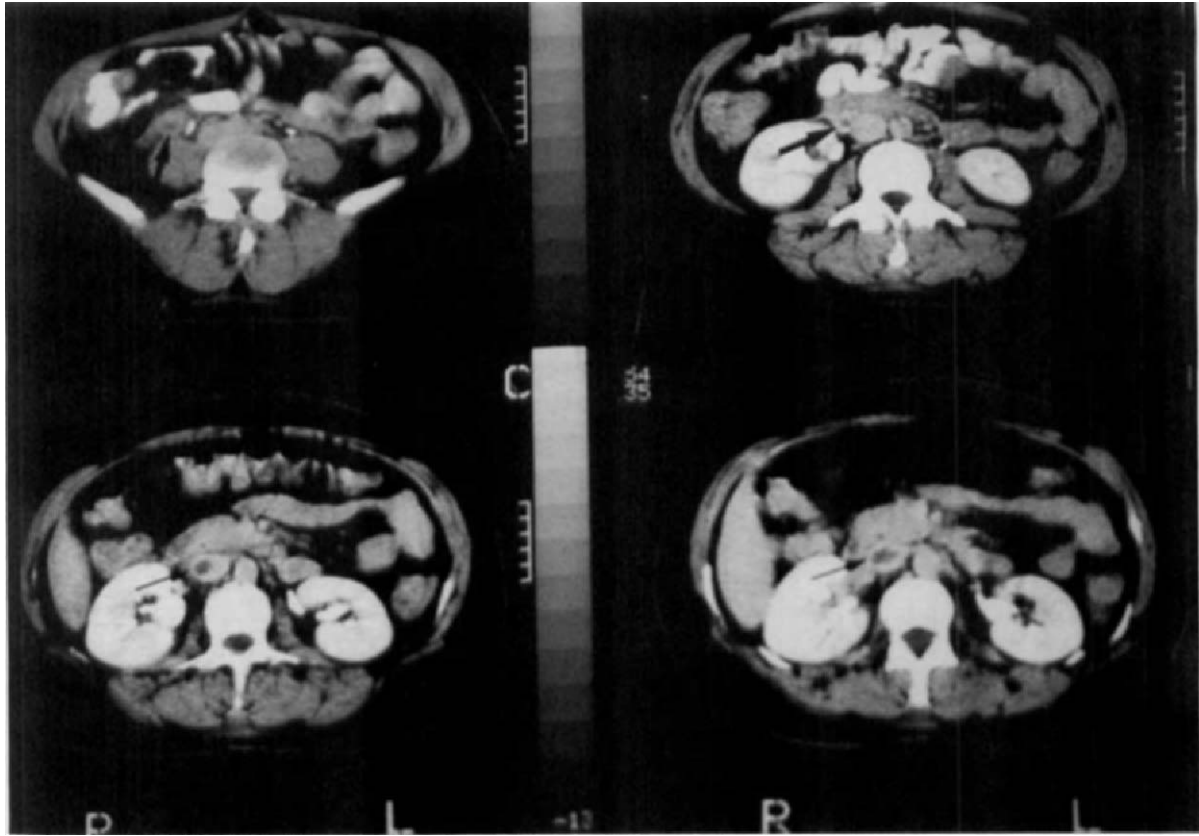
Preoperative abdominal CT scan. The small arrow shows the floating clot in the IVC; the large arrow shows the voluminous thrombosed right ovarian vein.
